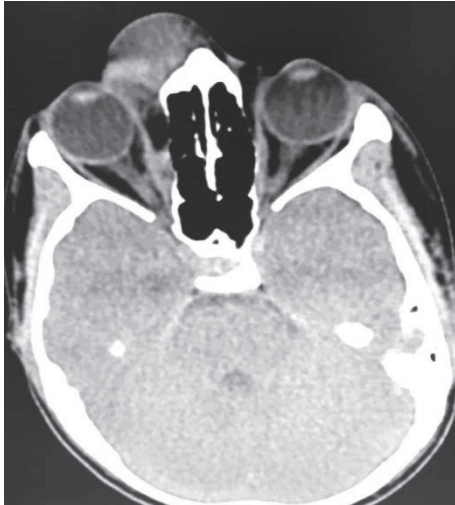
CT findings showed soft tissue swelling at medial part of right orbit involving medial part of upper and lower eyelid and medial canthal region.
